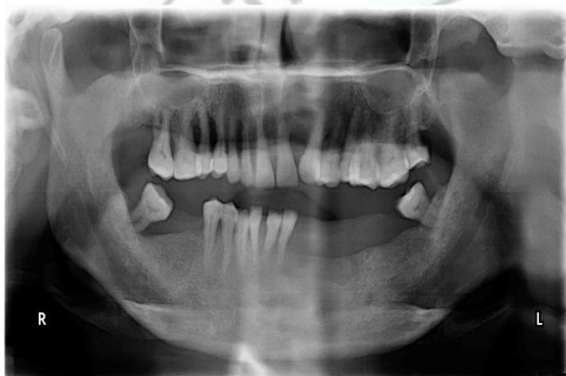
Orthopantomography revealed generalized bone loss.
